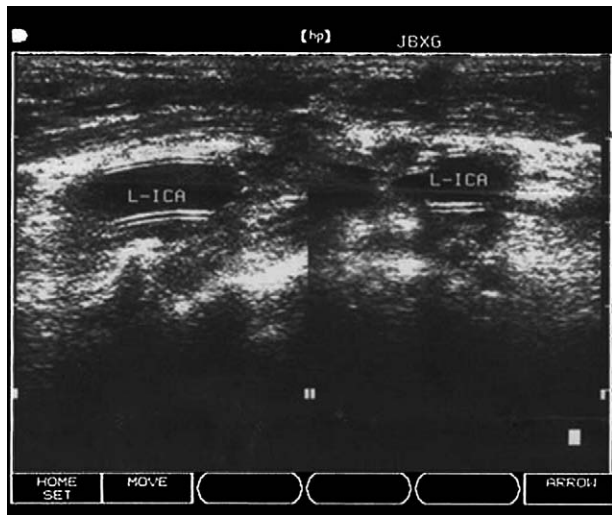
Transcranial Doppler (2 years postoperation) revealed smooth inner wall of internal carotid artery with vascular continuity and normal velocity of blood flow.
